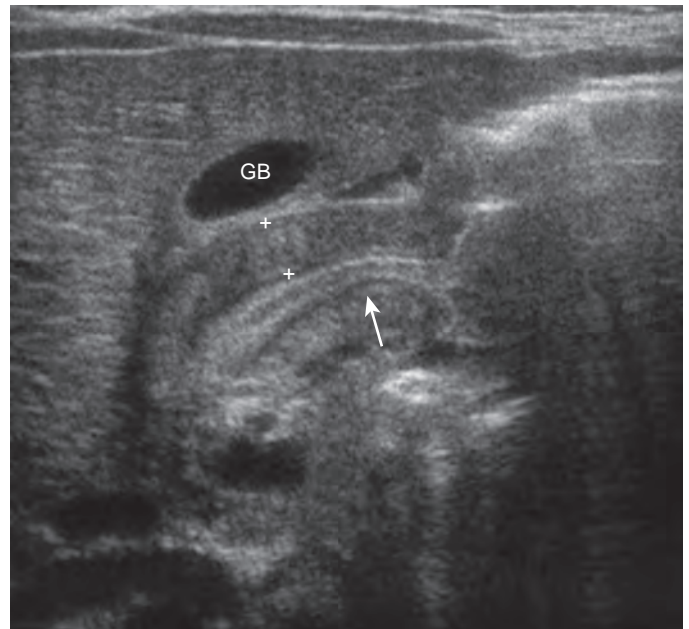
Pyloric stenosis: ultrasonography. In this image obtained along the long axis of the pylorus, the hypoechoic pyloric muscle (between calipers) is abnormally hypertrophied and thickened, measuring more than 3.5 mm, and can be seen on either side of the parallel, linear echoes (arrow) that represent the redundant mucosa of the narrowed pyloric channel. The gallbladder (GB) is a useful anatomic landmark for locating the pylorus.
